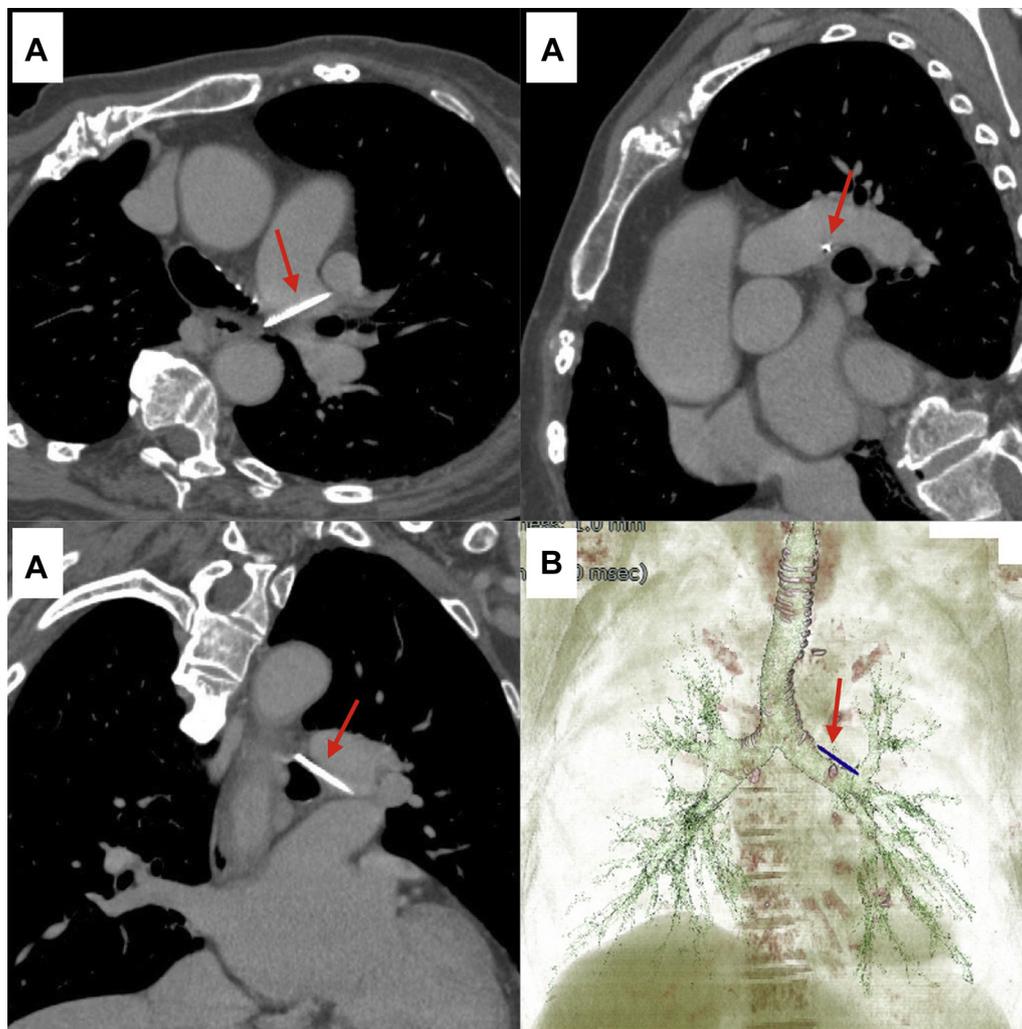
(A) Multiplanar and (B) 3-dimensional reconstruction using enhanced multidetector computed tomography showing a needle (arrow) surrounded by the left main bronchus, the left pulmonary artery, the esophagus, and the left upper pulmonary vein.
